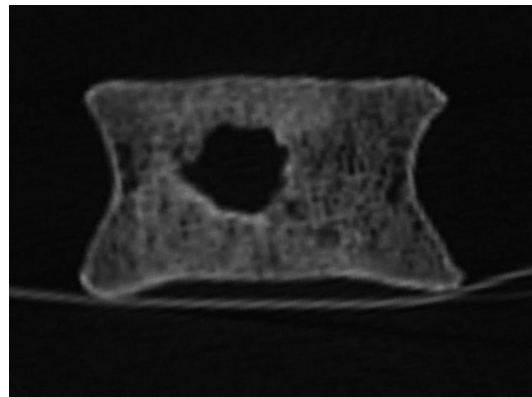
CT scan coronal view multiplanar reconstruction: distrectual central hypodensity area with peripheral hyperdensity ring
